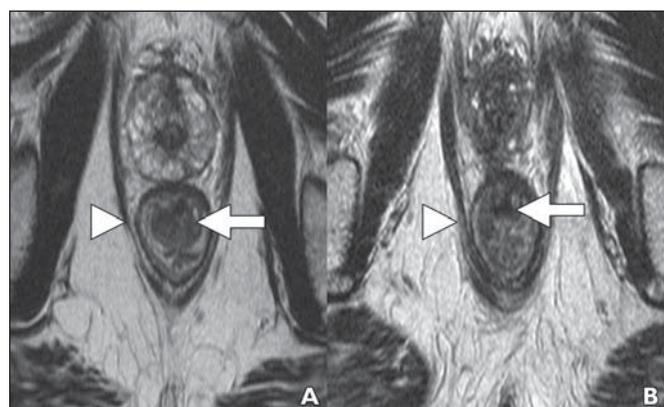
68-year-old man with rectal cancer. A, Baseline axial T2-weighted MR image at level of puborectalis (*arrowhead*) shows T1 tumor (*arrow*). Tumor is predominantly intramural with likely invasion of submucosa. B, Posttreatment axial T2-weighted MR image obtained shows low-signal-intensity scar (*arrow*) at 12-o'clock position and normal submucosa. Puborectalis sling is indicated by *arrowhead*.
